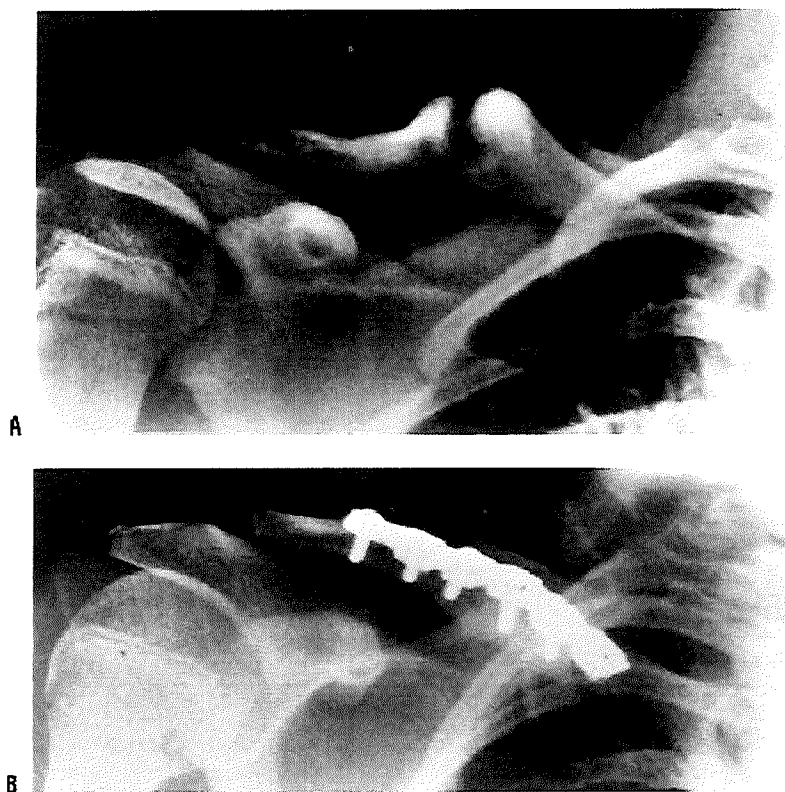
BC is a 10-year-old boy who noticed a lump on his collar bone and experienced discomfort with throwing activities since an injury 3 years earlier. At the time of the injury he was told that he had fractured his clavicle; at the time of these radiographs he was referred for a persistent nonunion. A: Radiographs demonstrate a typical congenital pseudarthrosis of the right clavicle. B: Results of excision, grafting, and plating are shown. Healing was prompt, and he returned to all activities without discomfort in 6 months.
